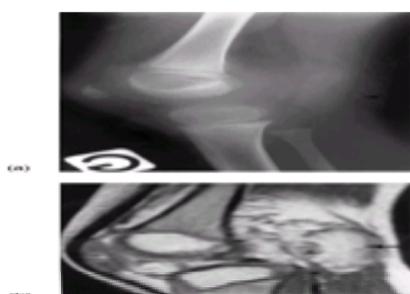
Synovial haemangioma affecting the knee in a 5-year-old boy. (a) Plain film demonstrates a phlebolith and a popliteal mass. (b) Enhanced T_1 -weighted MR
